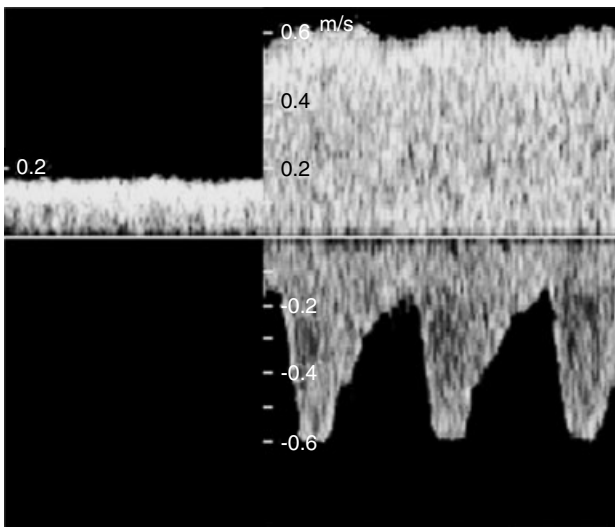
Doppler recording of the umbilical venous blood velocity at the fetal end of the cord (left panel) in a fetus at 32 weeks of gestation. The velocity is low compared to the recording at the abdominal inlet (right panel), which shows the simultaneously recorded blood velocity in the umbilical artery
